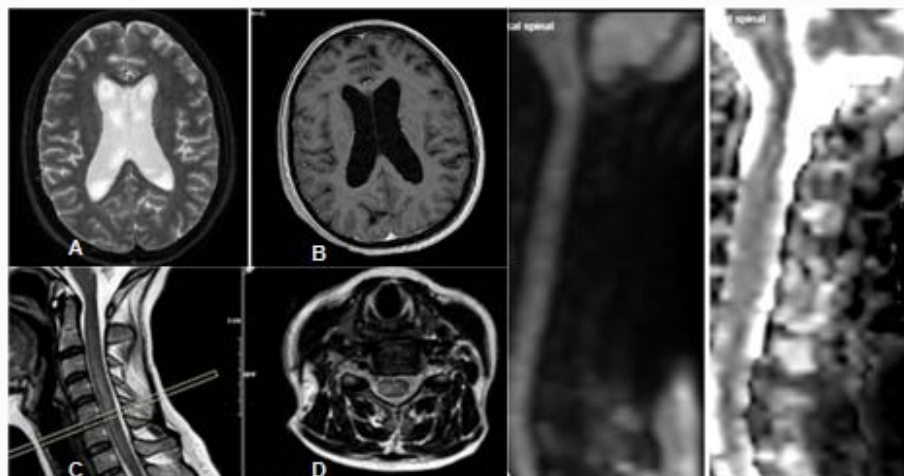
A/B: Hydrocephalus is seen on T2-weighted axial section and contrast-enhanced T1-weighted axial image. C/D: The brain parenchyma is normal. Diffuse hyperintensity of the spinal cord between C2-C7 on T2-weighted sagittal and axial images consistent with edema. E/F: On the sagittal DWI image and the corresponding ADC map a slight increase in diffusion is observed in the cervical spinal lesion.
